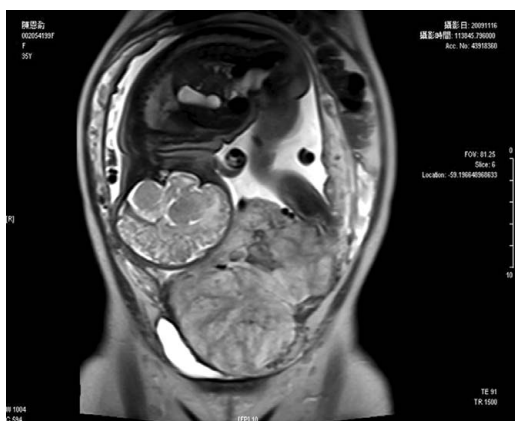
Coronal T2-weighted magnetic resonance image showing outward bulging of the lower uterine segment and heterogeneous signal intensity and dark intraplacental bands (flow voids) within the bulky placenta. Extrinsic compression of the bladder with suspicious focal invasion is also seen along its superior margin.
